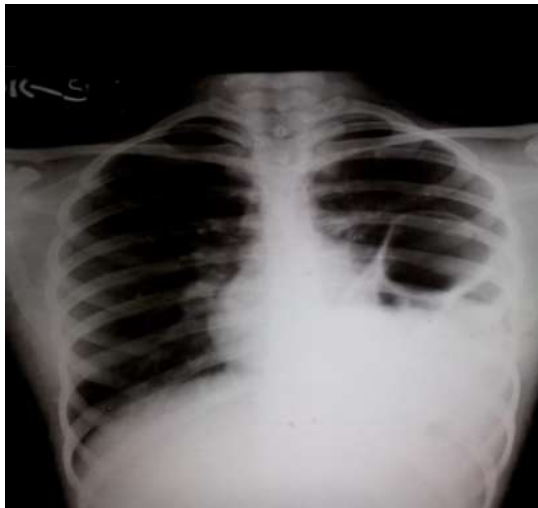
Chest x-ray (PA view) showing large cavity with multiple air fluid level in left mid and lower zone.
